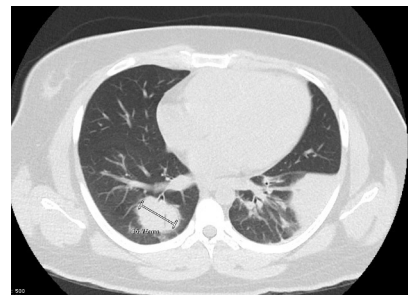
CT chest without contrast with multiple basilar nodules with the largest measuring 6.3 cm, worse than previous CT chest.
